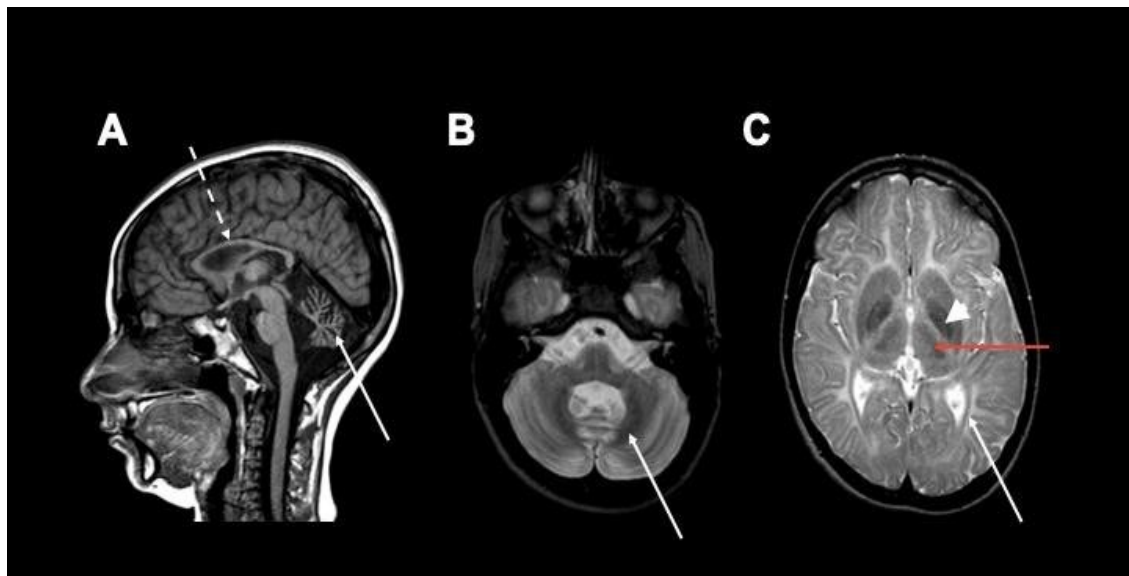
Typical brain MRI pattern of POLR3-related leukodystrophy. Sagittal T1 image at the level of the midline (A), axial T2 images at the level of the cerebellum (B) and basal ganglia (C). A. Cerebellar atrophy (white arrow), as well as thinning of the corpus callosum (dashed arrow), are seen. B-C. diffuse hypomyelination, i.e., a hyperintense signal of the white matter in the cerebrum and cerebellum is appreciated, with relative preservation, i.e., hypointensity, of the dentate nucleus (B, white arrow), optic radiations (C, white arrow), globus pallidus (C, arrowhead) and anterolateral nucleus of the thalamus (C, red arrow). This patient does not have preservation of the corticospinal tracts at the level of the posterior limb of the internal capsule, which is another feature that can be seen in this disorder (C).
